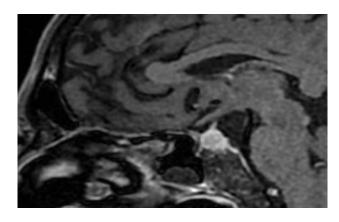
Sagittal section T 1 weighted post contrast image of MRI brain showing enhancement of bulky pituitary and stalk along with mid enhancement of adjacent dura.
